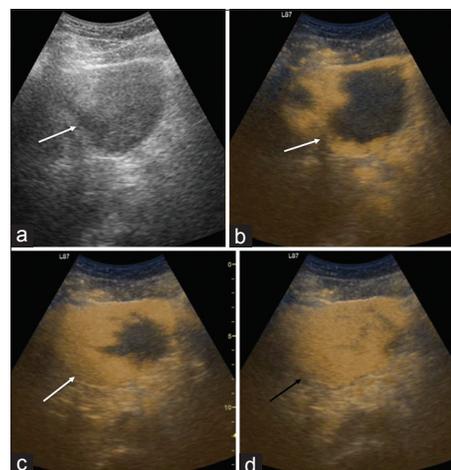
A 54-year-old male patient who is a known case of chronic renal failure presented with mild abdominal pain from 1 week. Routine screening ultrasound shows a large hypoechoic lesion with irregular margins in the left lobe of the liver (white arrow, a). Contrast-enhanced ultrasound done targeting the lesion is showing peripheral nodular enhancement in arterial phase (white arrow, b), gradual centripetal filling in venous (white arrow, c) and complete filling in the delayed phases at 150 s after contrast injection (black arrow, d)
